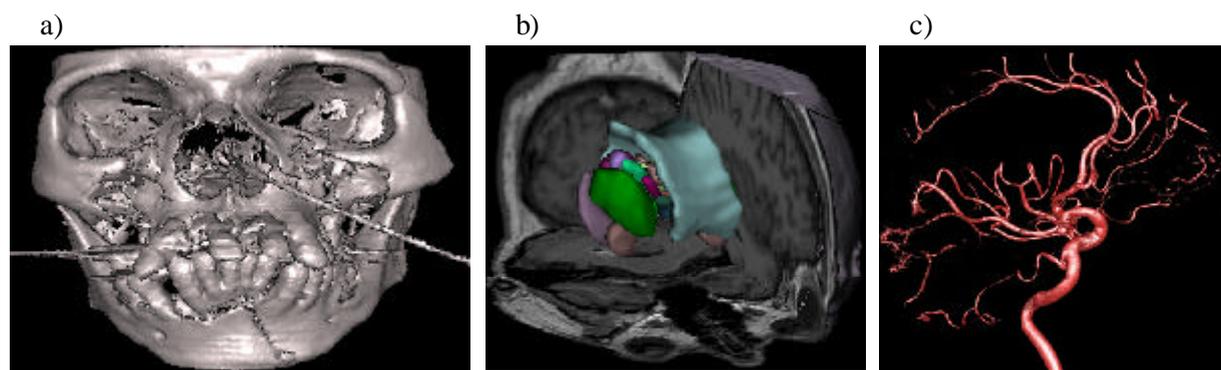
Volume visualization: a) surface rendered skull from CT data of a car-accident victim; b) hybrid volume and surface rendering of MRI head and the 3D atlas represented as polygonal models; c) volume rendering of cerebral angiographic data.
